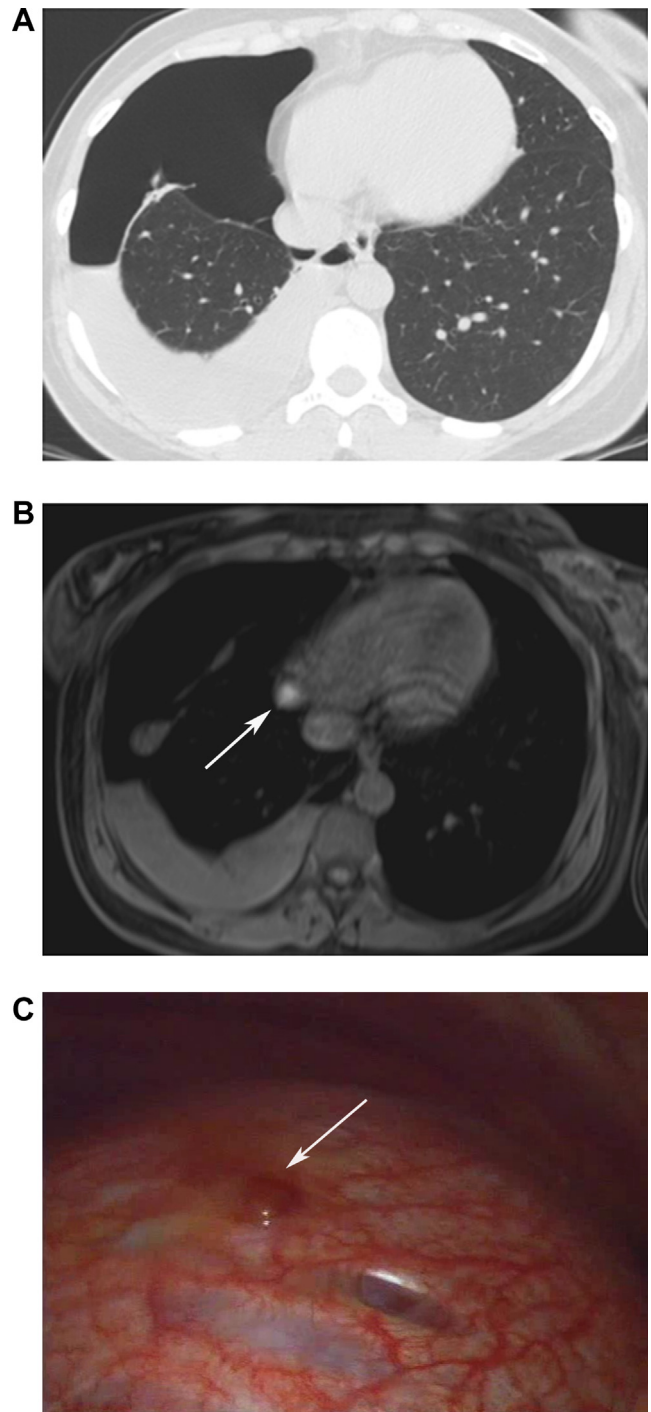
A 35-year-old woman with pleural endometriosis. The patient presented with chest pain and dyspnea occurring monthly, coincident with menses. A. Computed tomography at the level of the lower lobes of the lungs shows a right hydro-pneumothorax. B. Axial T1-weighted magnetic resonance image reveals an oval, well-defined pleural lesion with intermediate signal intensity (arrow) and hydro-pneumothorax. Pleural effusion also shows intermediate signal intensity, probably due to the blood component of fluid. C. Thoracoscopic view of an endometrial implant (arrows).
